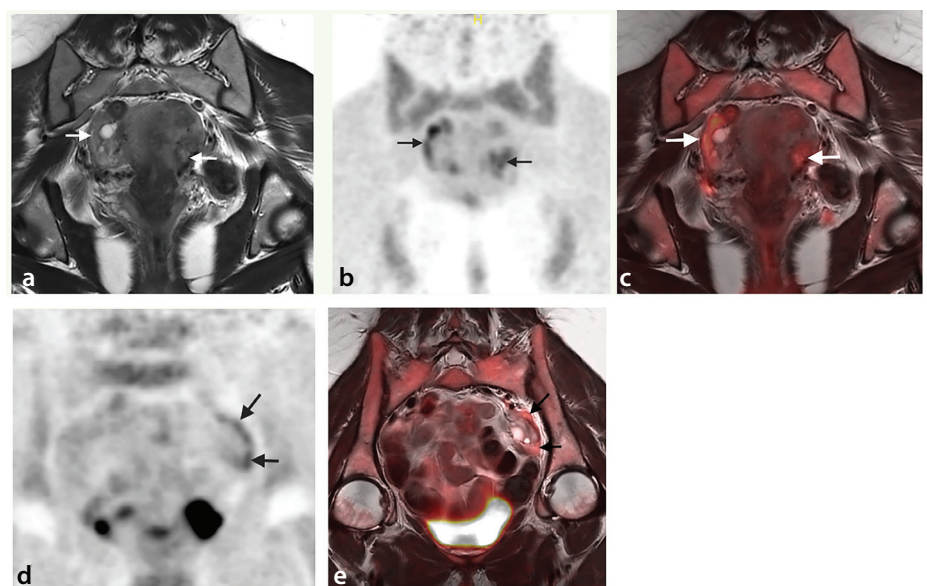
Physiological fluorodeoxyglucose (FDG) uptake in fallopian tubes. The coronal T2-weighted image (a) shows bilateral fallopian tubes (arrows). The coronal positron emission tomography (PET) (b) and coronal fused PET/magnetic resonance images (MRI) (c) show increased comma- or tadpole-shaped FDG uptake in both fallopian tubes (arrows). The arrow on the left indicates to intramural (interstitial) part of the left tube. The coronal PET (d) and coronal fused PET/MRI (e) show increased FDG uptake in the ampullar part of the left fallopian tube (arrows) that forms a curve over and around the ovary.
